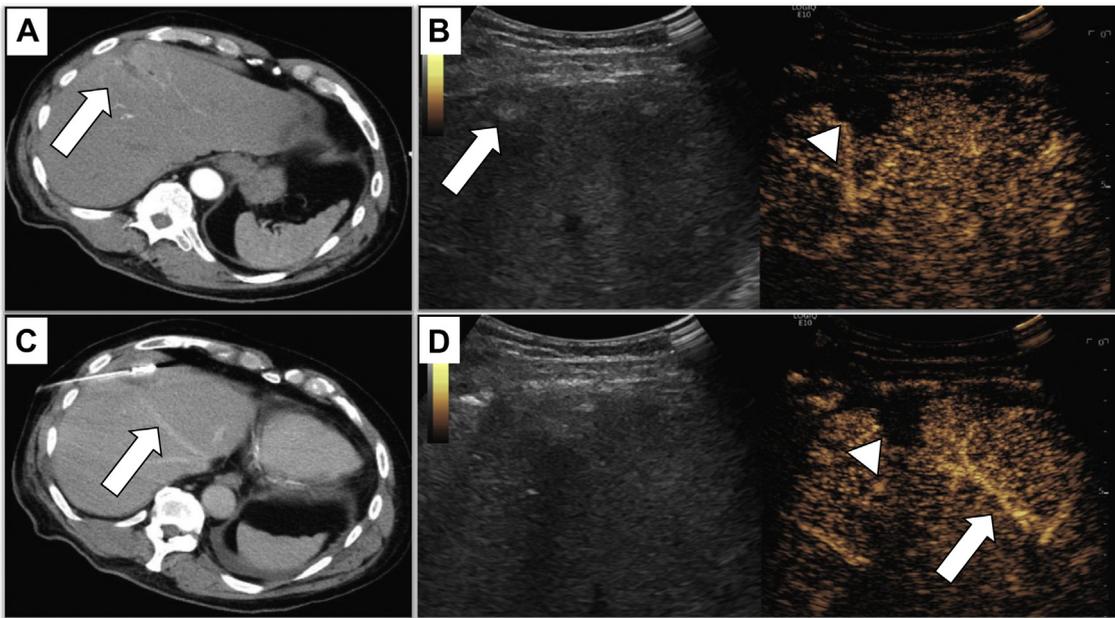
Matched CT and US contrast images to demonstrate appearance of liver lesion during microwave ablation procedure. Contrast-enhanced CT in the arterial phase with poorly delineated right liver lesion (A, arrow). Corresponding gray scale B-mode and matched CEUS images in the arterial phase with poorly visualized lesion on the gray scale B-mode image (B, arrow) and well-delineated lesion on the CEUS image (B, arrowhead). Contrast-enhanced CT in the venous phase during microwave ablation, which demonstrates middle hepatic vein (C, arrow). Corresponding CEUS that does not demonstrate lesion or vein on conventional gray scale B-mode but does demonstrate the lesion (D, arrowhead) and middle vein (D, arrow) on the matched CEUS images. CEUS, contrast-enhanced ultrasound; CT, computed tomography; US, ultrasound.
